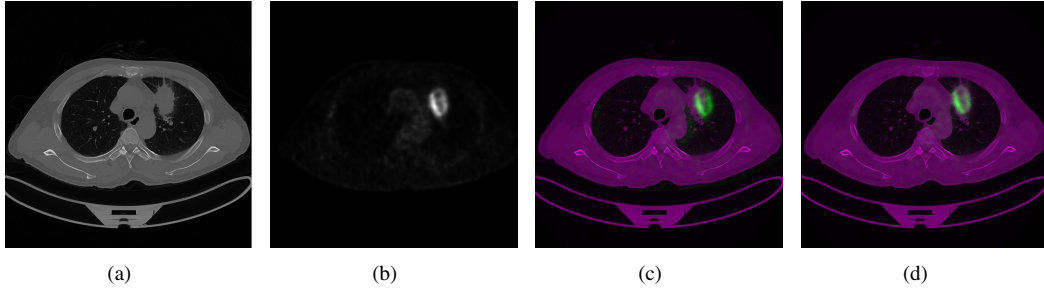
The register process. (a) the original slice of CT. (b) the slice of PET after up sampling. (c) the overlay display of two images before registering. (d) the overlay display of two images after registering.
